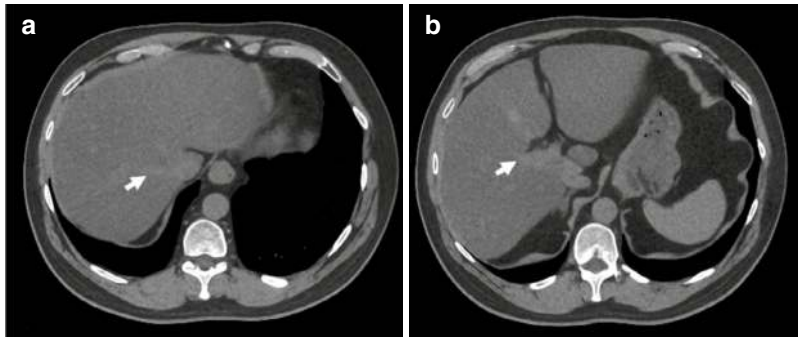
(a and b) Unenhanced CT demonstrating a hypodense fatty liver. Intrahepatic vessels (arrow) appear brighter than the background liver due to diffuse background steatosis. The liver attenuation (28 HU) was significantly lower than that of the spleen (51 HU)
